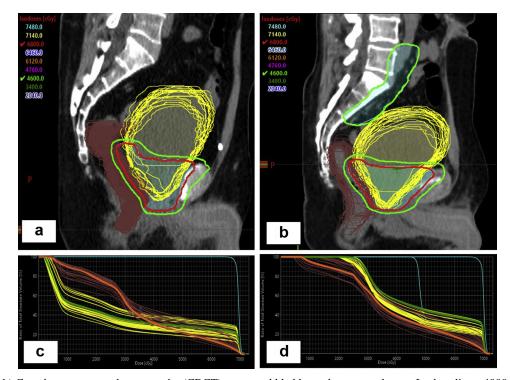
(a,b) Cone beam computed tomography (CBCT) contoured bladder and rectum volumes. Isodose lines, 4000 and 6800 cGy, are shown in green and red, respectively. (c,d) Corresponding dose volume histogram (DVH) curves when daily CBCT contours are evaluated against the planning computed tomography (CT). Solid orange line indicates planning DVH for the rectum, and solid green line indicates planning DVH for the bladder.
